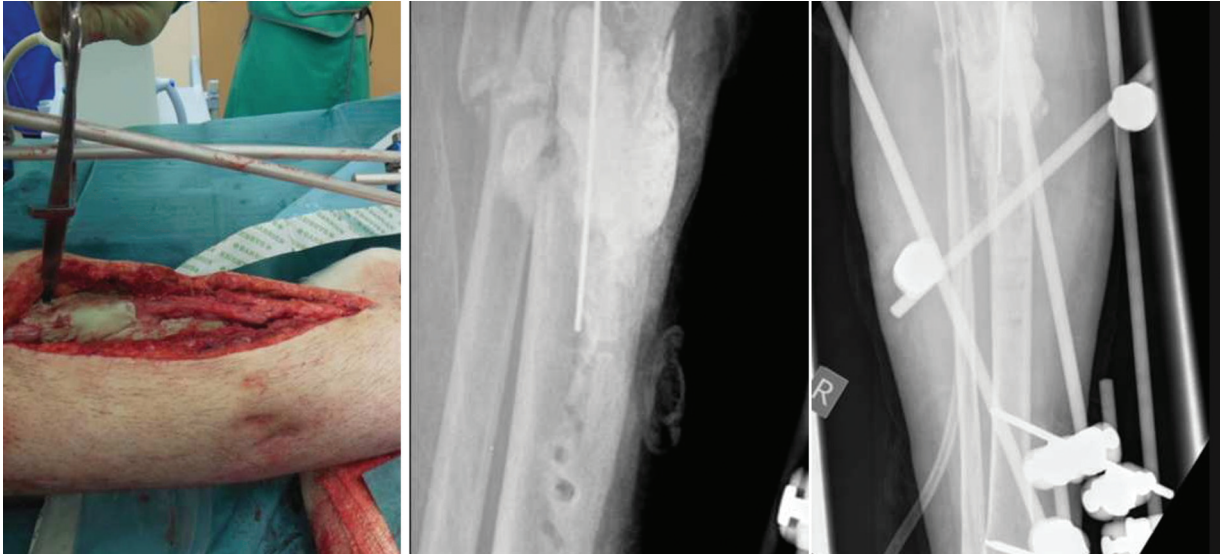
First-stage Masquelet procedure showing the insertion of the cement following appropriate debridement of the nonunion site (A). Corresponding AP and lateral radiographs (B, C). AP=anteroposterior.
